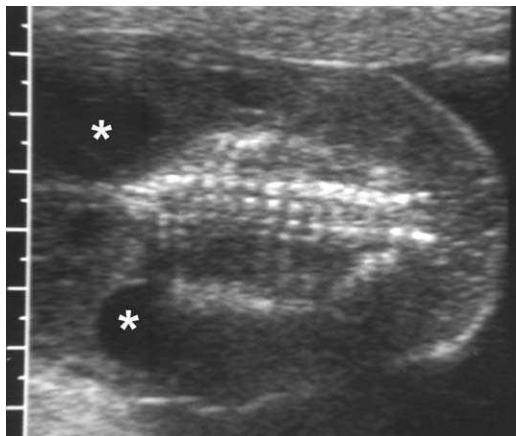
Coronal sonogram of an acardiac parabiotic twin. There is no head. There is diffuse integumentary edema and cystic hygromas (\*). No heart is present within the thorax.
